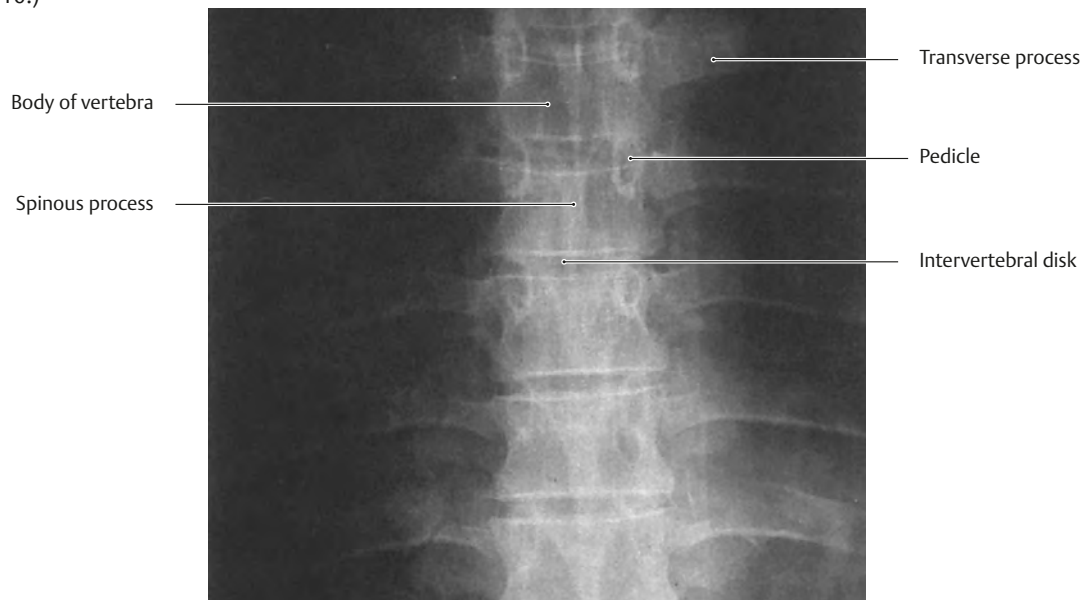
Radiograph of the thoracic spine
